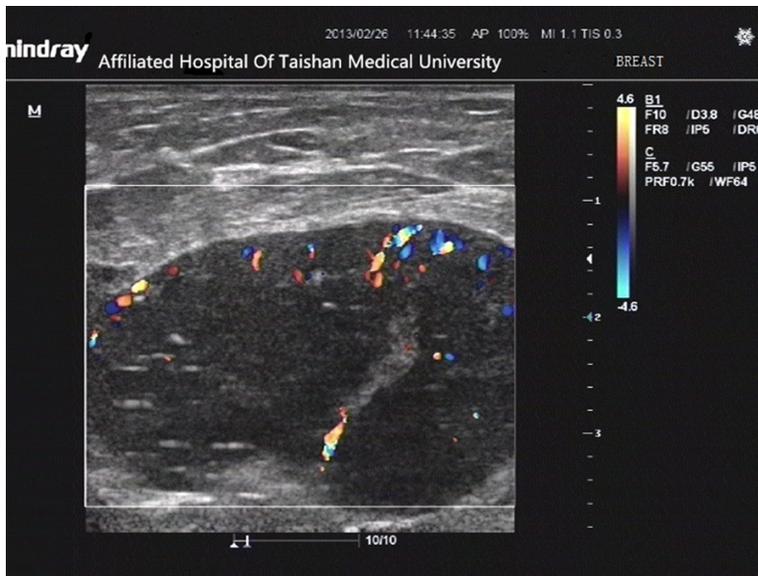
Ultrasound of a BC patient with lymph node metastasis.
